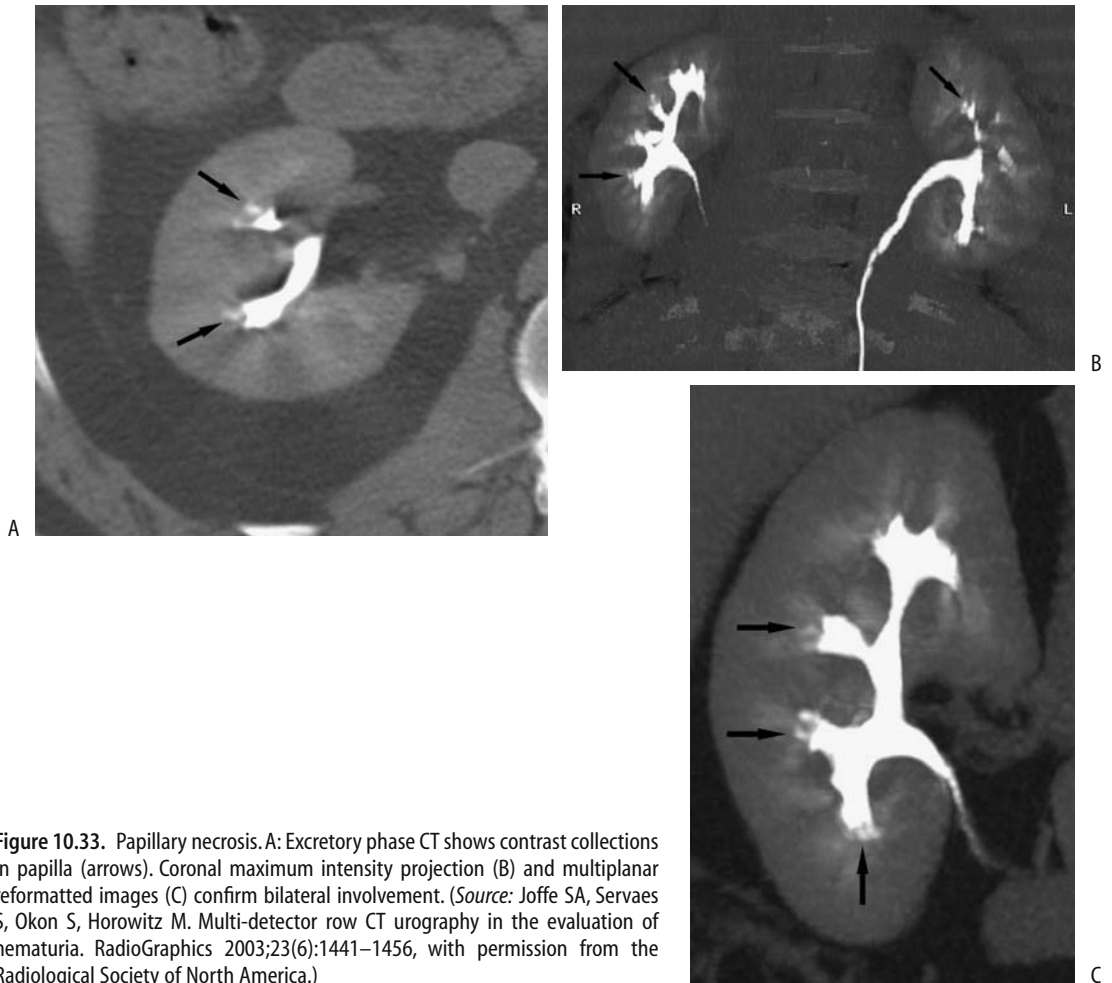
Papillary necrosis. A: Excretory phase CT shows contrast collections in papilla (arrows). Coronal maximum intensity projection (B) and multiplanar reformatted images (C) confirm bilateral involvement. (Source: Joffe SA, Servaes S, Okon S, Horowitz M. Multi-detector row CT urography in the evaluation of hematuria. *RadioGraphics* 2003;23(6):1441–1456, with permission from the Radiological Society of North America.)
